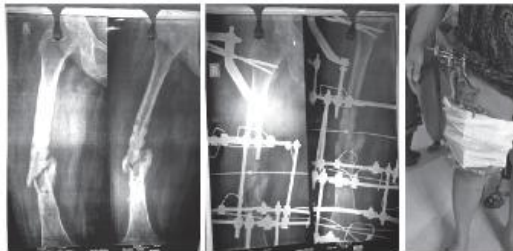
Pre-operative x-ray of thigh (R/V)
